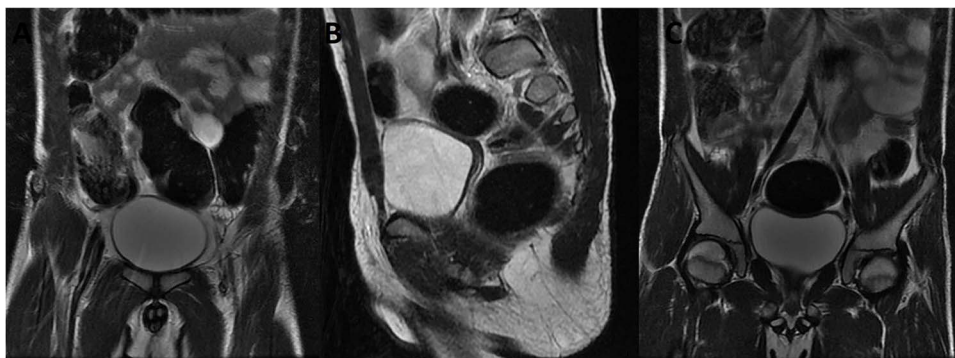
Magnetic resonance imaging (MRI) (sagittal section) shows the right (C), the left ovary (A) and uterus (B).
